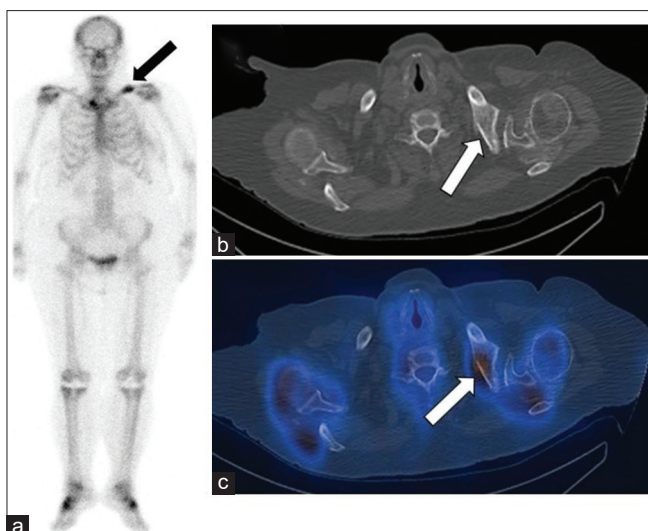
A 74-year-old woman with left breast carcinoma (T2N1aMx). (a) Planar WBS in frontal view showed increased tracer uptake at the left clavicle (black arrow). (b) CT scan showed break in the cortex at the left mid clavicle (white arrow) with no significant suspicious bony changes. (c) Fused SPECT/CT image localised the avid radiotracer uptake at the left clavicle, likely to represent a recent fracture. Hence, SPECT/CT helps to differentiate between benign and malignant processes, WBS: Whole-body bone scanning, SPECT/CT: Single photon emission computed tomography/computed tomography
